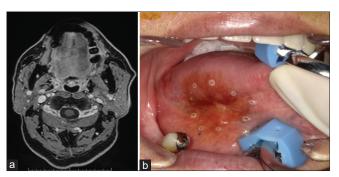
(a) MR image after completion of intra-arterial DCF therapy in case 1. (b) Intraoral photograph at the time of surgery. The excisional margin was inside the marking points
